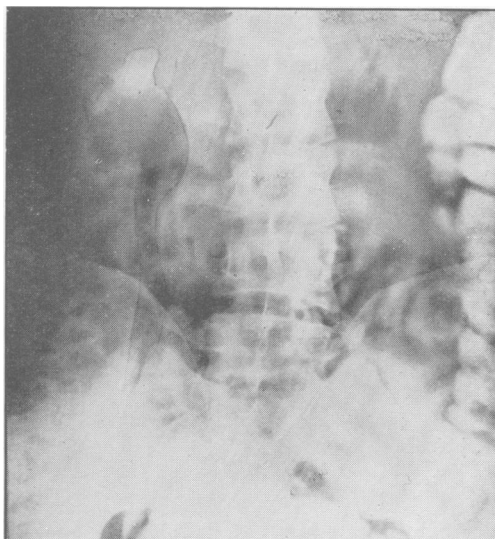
X-ray following opaque enema, fifteen months post-operative. Note the pneumopyelogram on the right side and radio-opaque fluid in the upper calyces (same case as Fig. 5).
